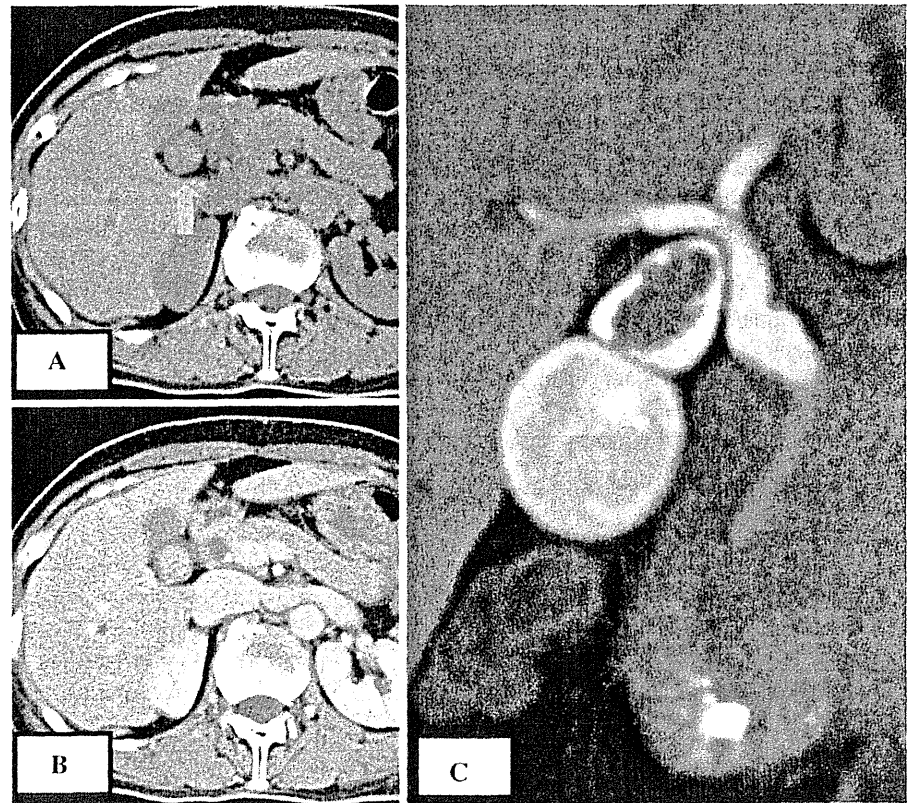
A 16 mm tumor (arrow) is shown at the neck of the gallbladder on abdominal CT (a plain, b enhanced phase) and drip infusion cholangiography CT (c coronal reconstruction) in patient 1
